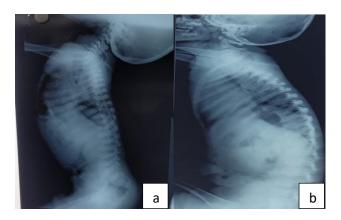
a) X-ray spine revealed anterior beaking of vertebral bodies, b) X-ray spine of the unaffected twin reveals a normal finding.
